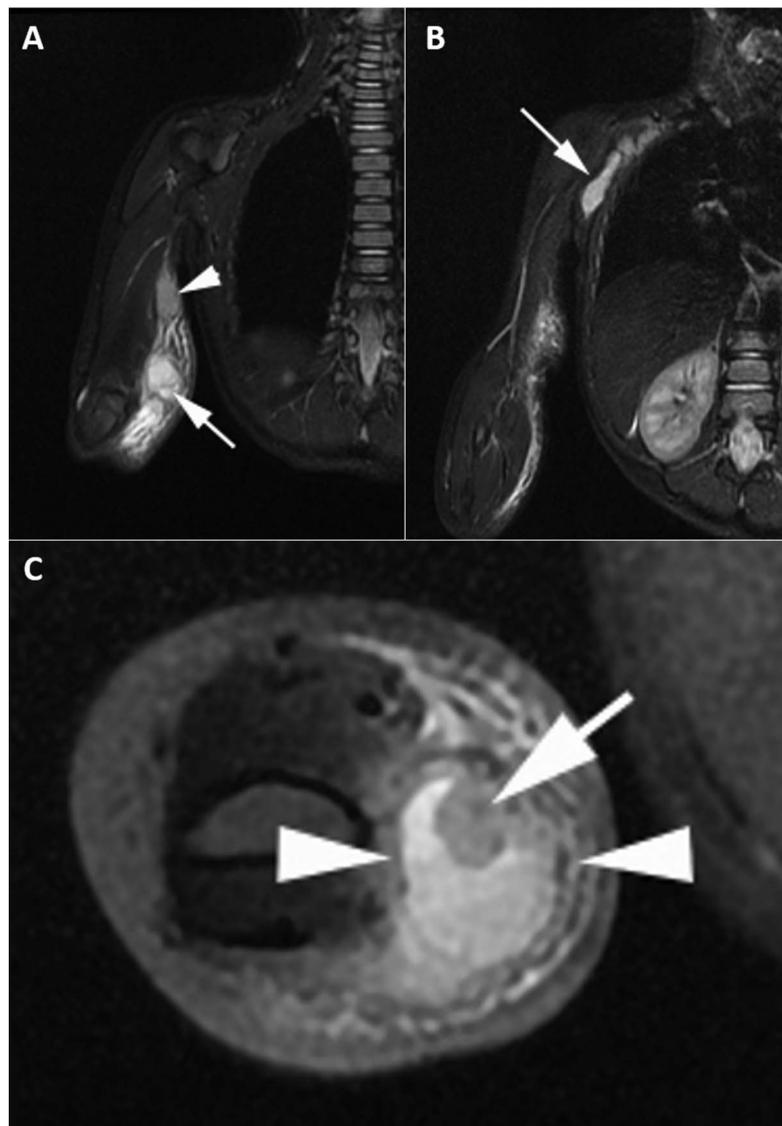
MRI scan of right upper arm. Coronal short tau inversion recovery demonstrating (A) a high T2 signal ovoid subcutaneous mass in the epitrochlear region (arrow), with a further mass lying more proximally (arrowhead) and (B) a sausage shaped high T2 signal mass in the right axilla (arrow). Axial T2 fat-saturated image (C) showing an ovoid subcutaneous inflammatory mass (arrowheads) with a central hilum (arrow), suggestive of a lymph node.
